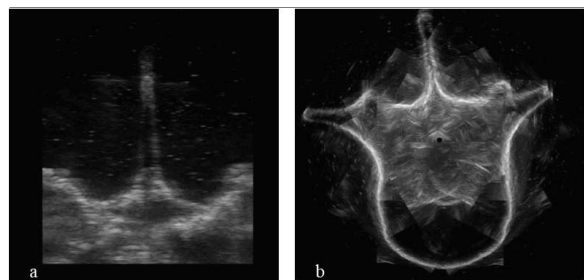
Ultrasound images before (a) and after images fusion (b).
